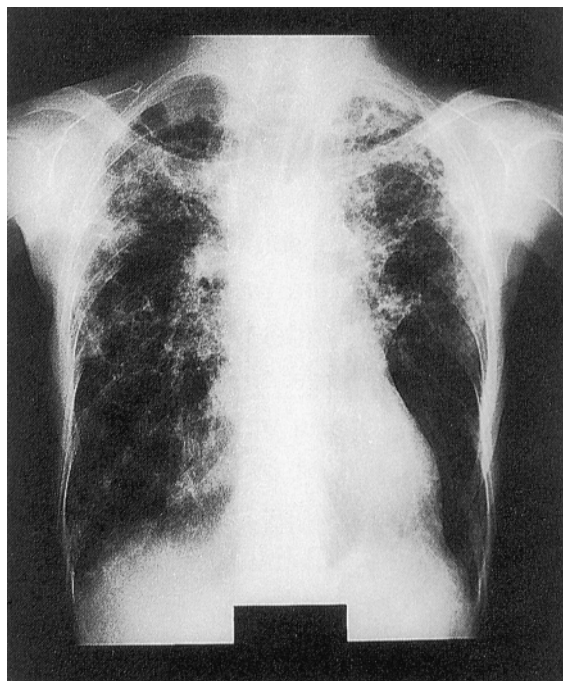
Chest x-ray film taken after the patients became to a steady state. Fig. shows diffuse infiltrated shadows in both lungs with honeycomb appearances and tram signs and destroyed lung appearance.
